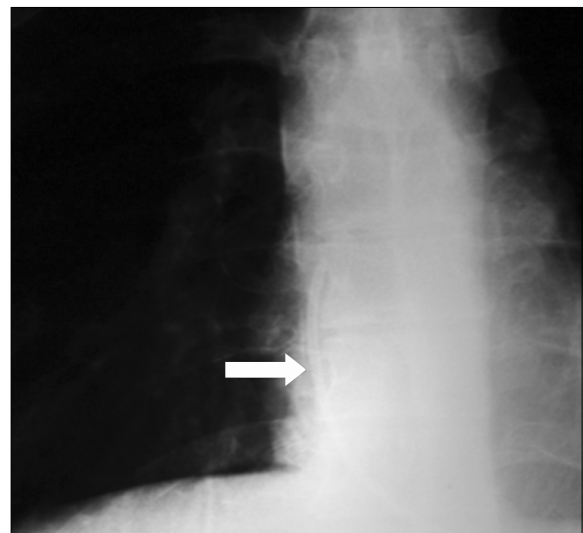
Part of a fractured catheter is seen in the superior vena cava (X-ray imaging, arrow).
